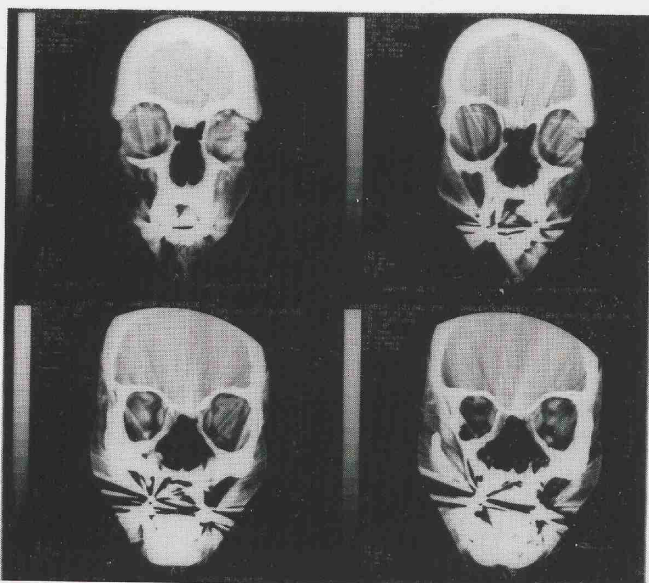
EG1942: coronal CT-scan of the sinuses 15 months after nasal surgery.
